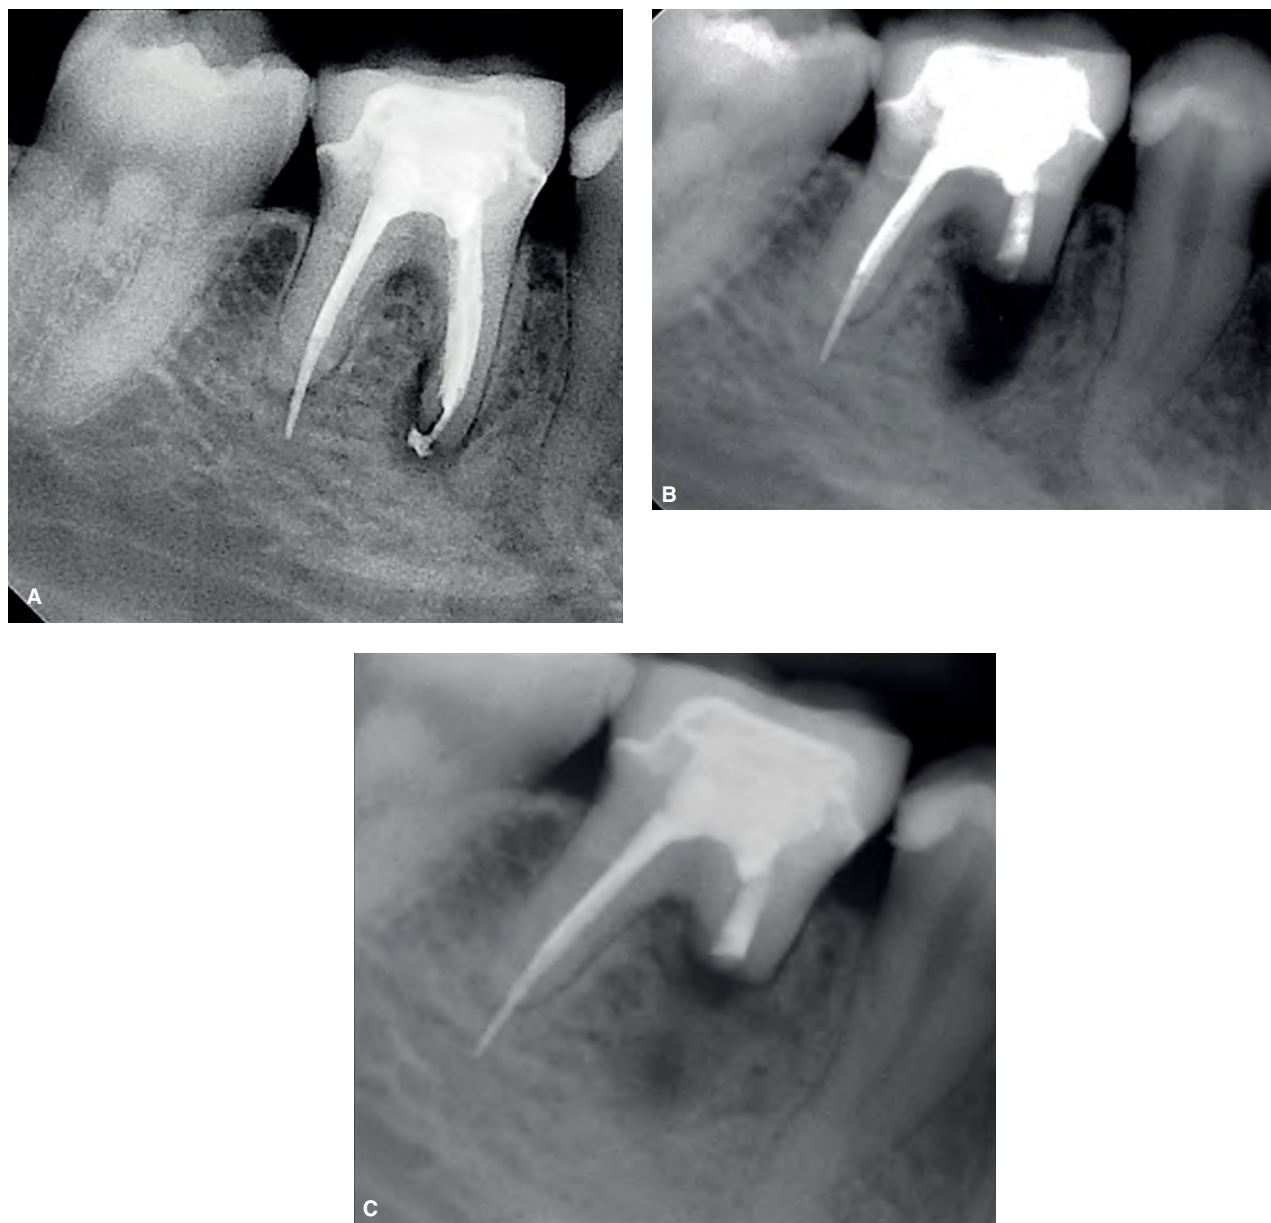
A. Poor obturation in apical third of the mesial root in an endodontically treated mandibular molar. B. During the surgery, a root fracture was noted in this region. The root was shaved until elimination of the fracture, leaving part of the root in the bone. C. Twelve-month postoperative radiograph showing evidence of periapical healing. (Courtesy of Dr. Mario E. Abdennour, Boston, MA.)
